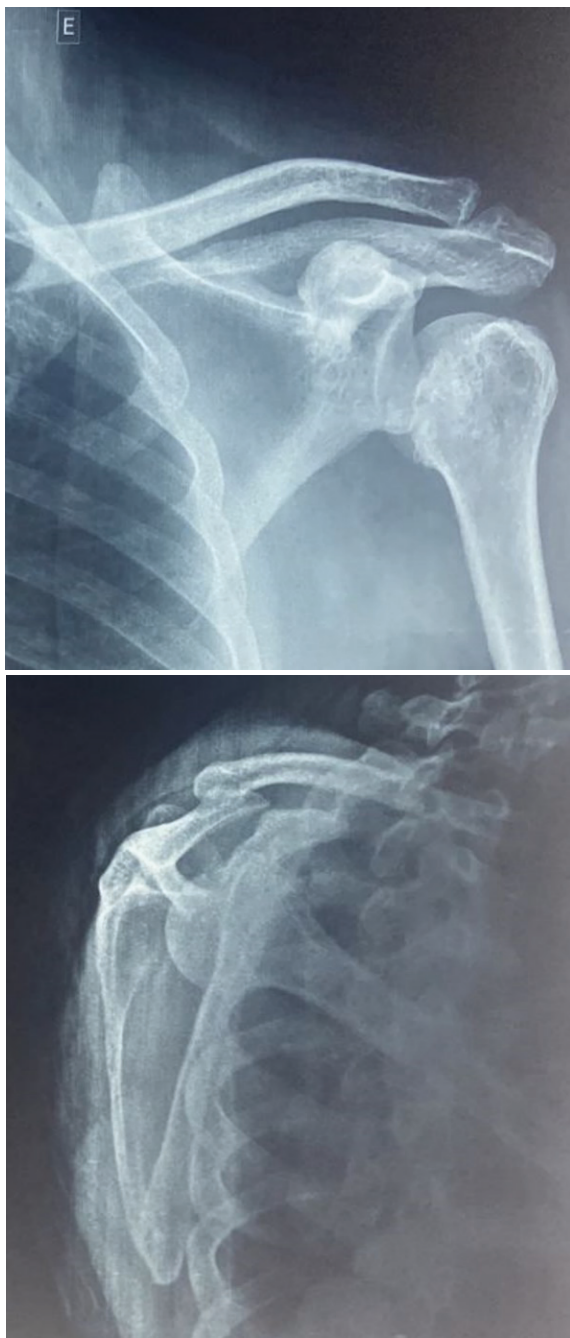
Corrected anteroposterior radiographs of the left shoulder and scapular profile demonstrating fracture-dislocation.
